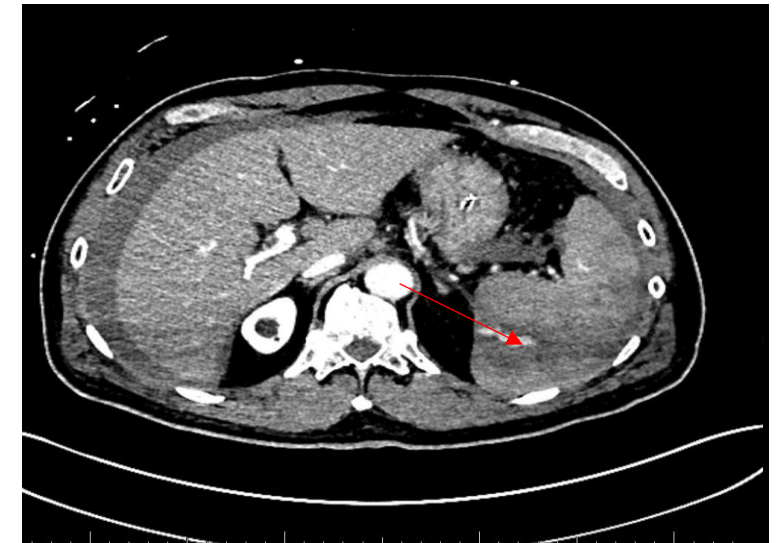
CT Abdomen/Pelvis showing Postero-Medial Splenic Hemorrhage
